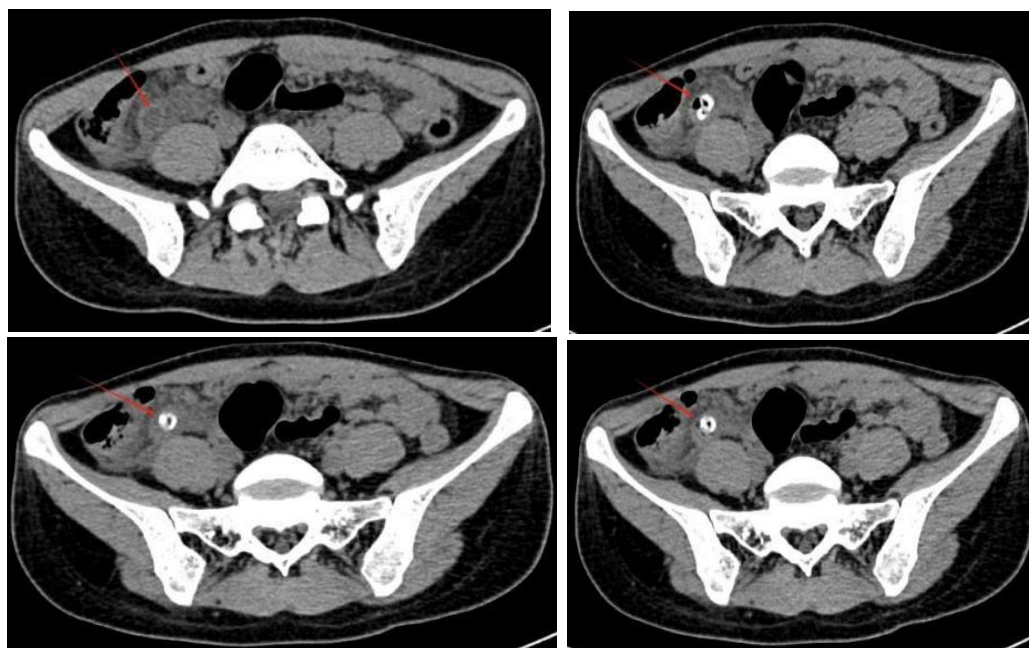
CT examination showed a significant thickening of the appendix lumen and a high-density shadow of faecal stones in it (the position pointed by the arrow).
